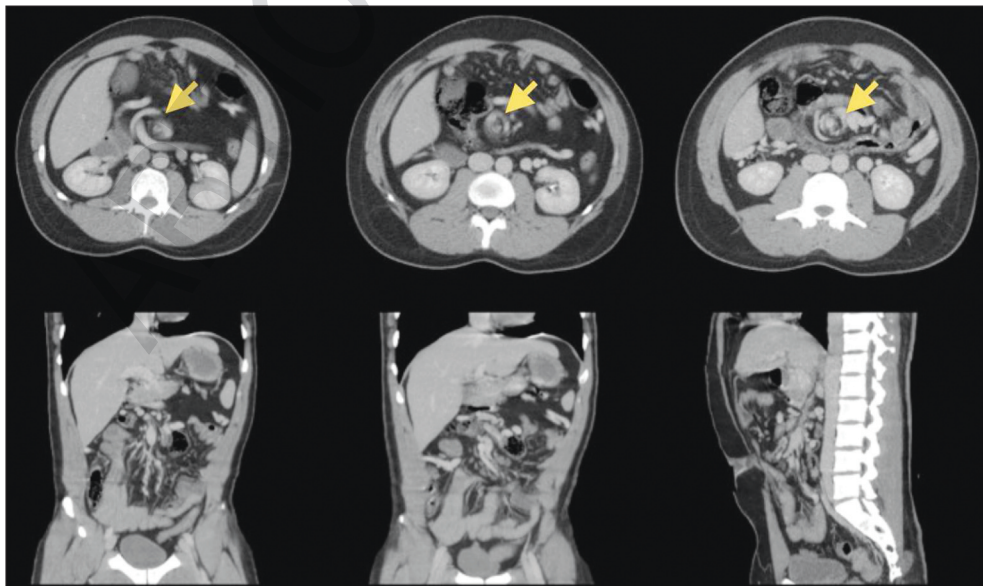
Intestinal volvulus appearance on CT. Whirlpool sign is seen in the axial plane of the CT images (yellow arrow). Venous congestion is demonstrated in the coronal plane and mesenteric rotation in the sagittal plane.
